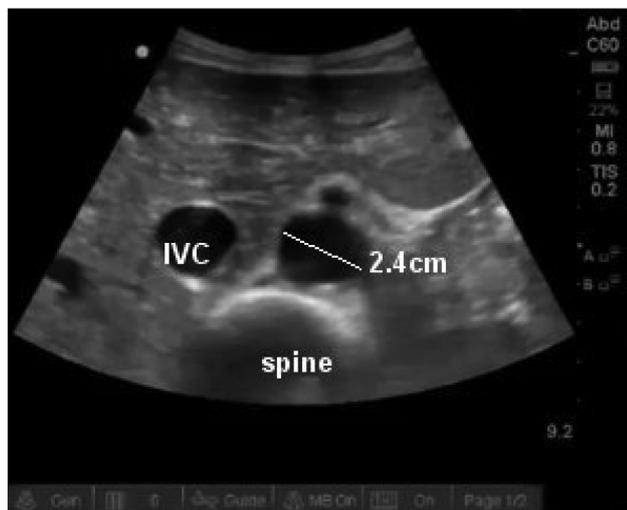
Ultrasound showing a normal abdominal aorta measuring 2.4 cm. Note the thicker wall of the aorta versus the inferior vena cava (IVC). Unfortunately, in a still image, we cannot use the criteria of lack of respiratory variability and noncompressibility to differentiate the aorta from the IVC.
